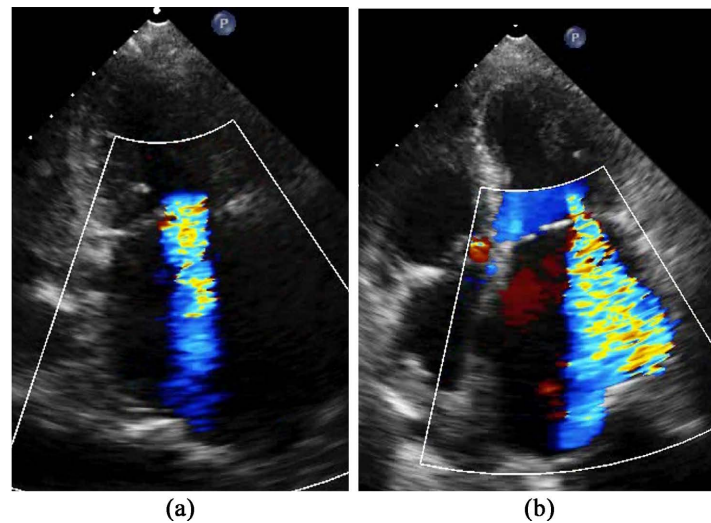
Echocardiograms of the patient with left heart disease (case 4) reveal moderate mitral valve regurgitation preoperatively (a), which worsened after surgery (b).
